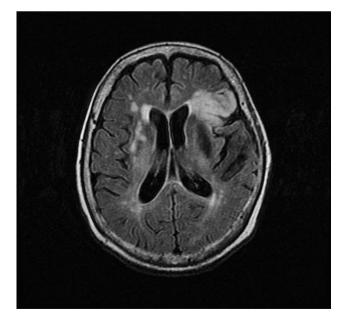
Diffusion-weighted magnetic resonance imaging study showed high signal intensity on left frontal lobe, compatible with acute cerebral infarction.
